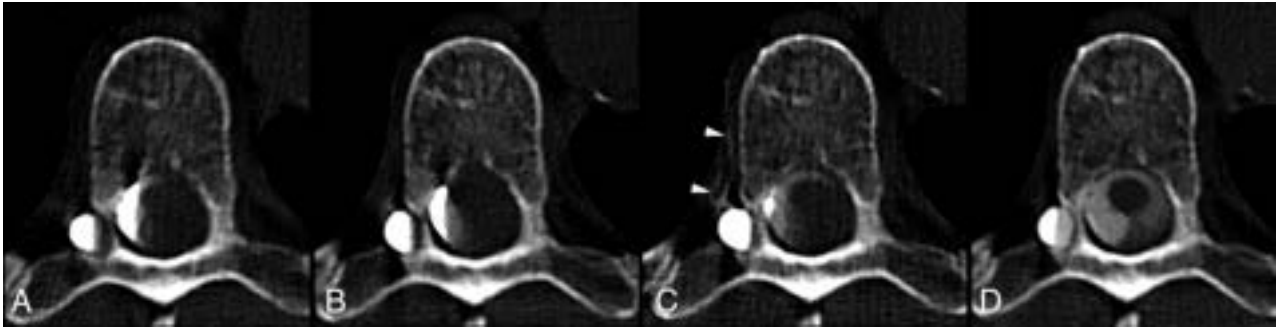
Axial images from a right lateral decubitus dynamic CT myelogram with bolus-tracking that were acquired at 30 seconds (A), 60 seconds (B), 2 minutes (C), and 4 minutes (D) after dense contrast was visualized on the bolus-tracking. A CSF-venous fistula is clearly identified on the image acquired at 2 minutes, with contrast visualized in a right T7 paraspinal vein (C, arrowheads). Note that the CVF only becomes more prominent after the adjacent diverticulum has nearly been completely filled with contrast.
